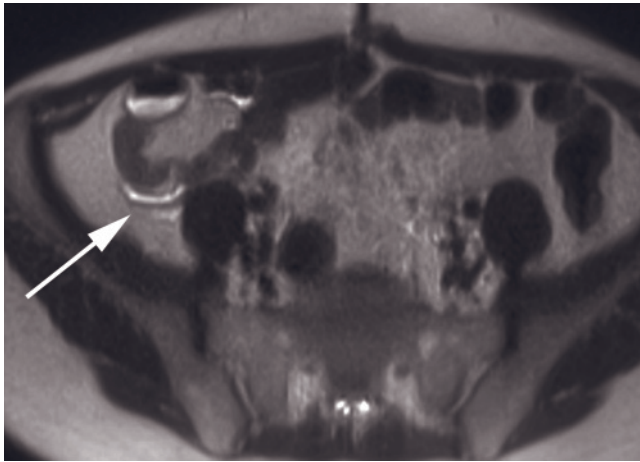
Acute appendicitis in pregnancy. Transverse T2-weighted SS-ETSE (a) and fat-suppressed T2-weighted SS-ETSE (b) images in a pregnant patient with right lower quadrant pain show an enlarged appendix (arrow) with periappendiceal inflammation. Fat-suppressed T2-weighted sequences (b) help increase the conspicuity of inflammation while avoiding gadolinium. In a different patient, transverse (c) and sagittal (d) gadolinium-enhanced fat-suppressed T1-weighted gradient echo images demonstrate appendicitis with a subhepatic abscess (arrow, c, d). In a third patient, coronal (e, f) and transverse (g) T2-weighted SS-ETSE images
